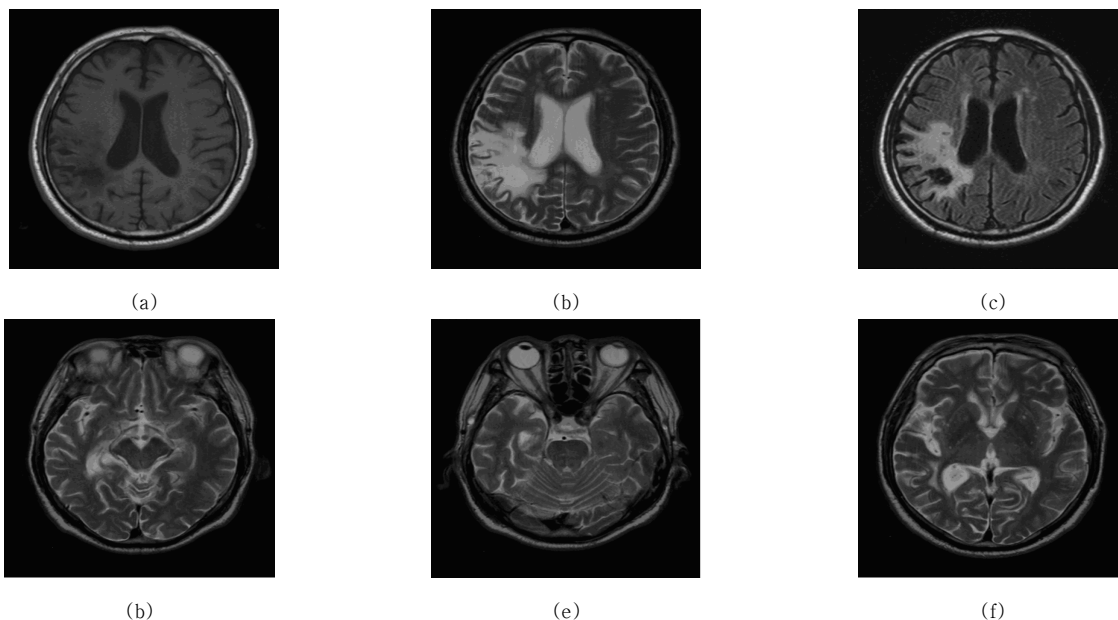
The patient, a 70-year-old man with old infarction. AC, Abnormal signal intensities related to an infarction in the right parietal lobe. Hypointensities on a T1-weighted image (a), hyperintensities on a T2-weighted image (b), and encephalomalacia with gliosis on FLAIR (c) are noted on axial scans of a routine MRI. DF, No evidence of abnormal signal intensity or asymmetric atrophy at the level of the basal ganglia (d), midbrain (e), or pons (f) on a T2-weighted image.
